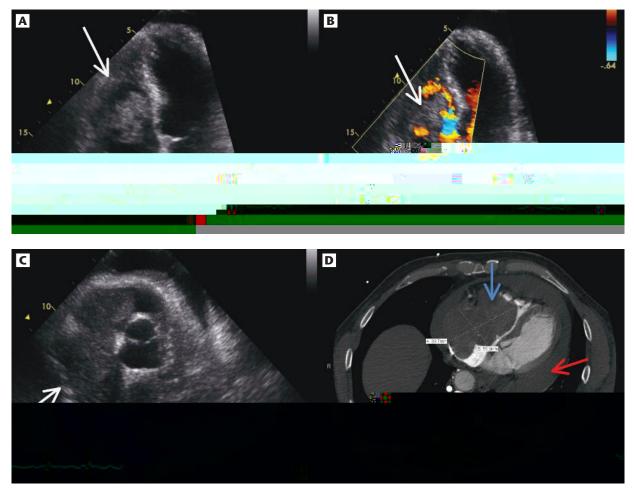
Transthoracic echocardiogram and computed tomographic images of the mass. (A) Transthoracic echocardiogram (apical 4-chamber view) showing the large mass in the right ventricle. (B) Color Doppler flow surrounds the mass. (C) Parasternal short-axis view of the mass invading both the right ventricle and right atrium. (D) Computed tomography image of the mass in the right ventricle measuring 89.7 mm \times 55.9 mm demonstrated by the *blue arrow* and the large surrounding pericardial effusion demonstrated by the *red arrow*.
